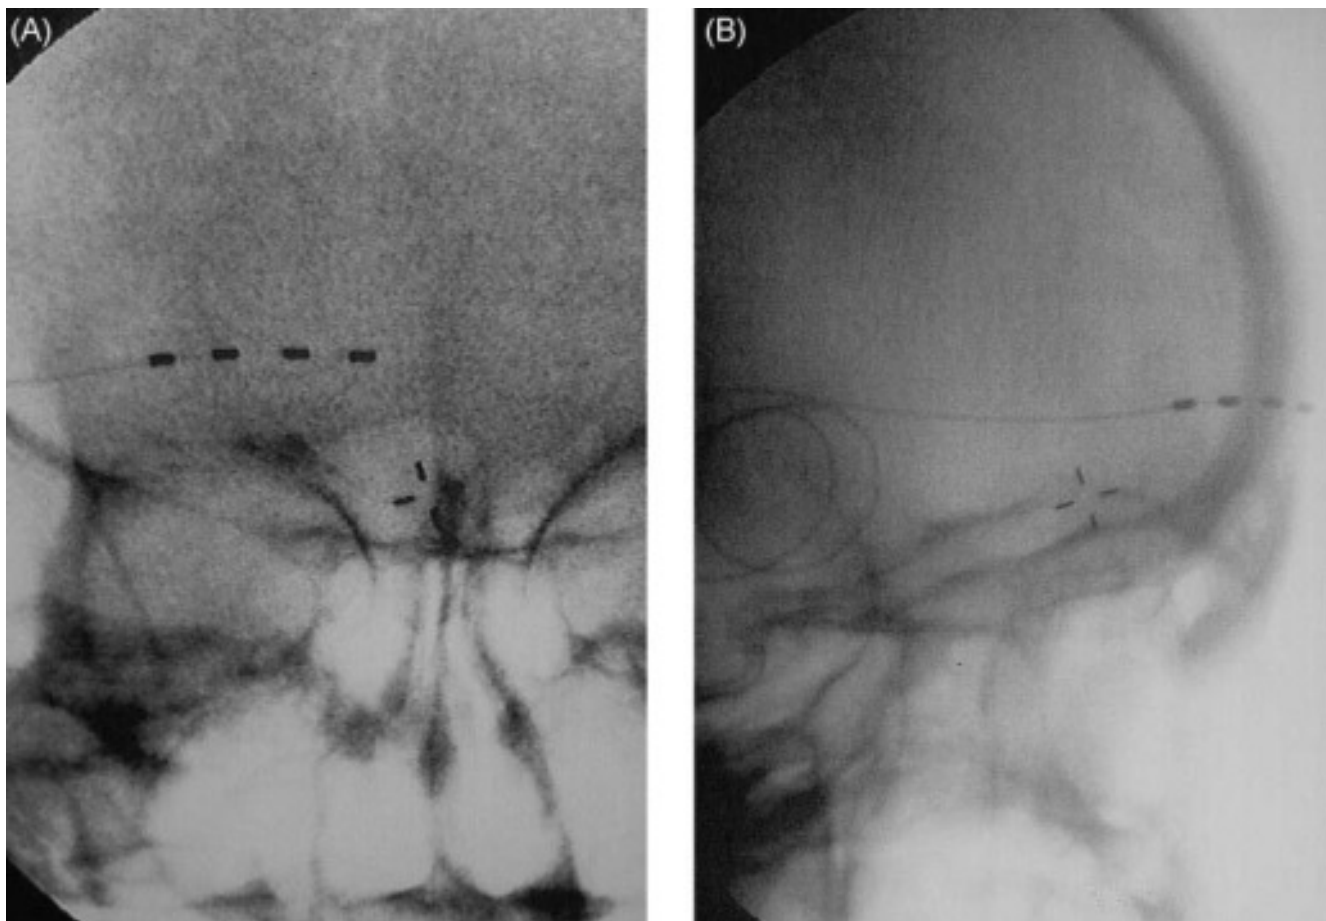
Radiographs of the supraorbital electrode (A, anteroposterior; B, lateral).
